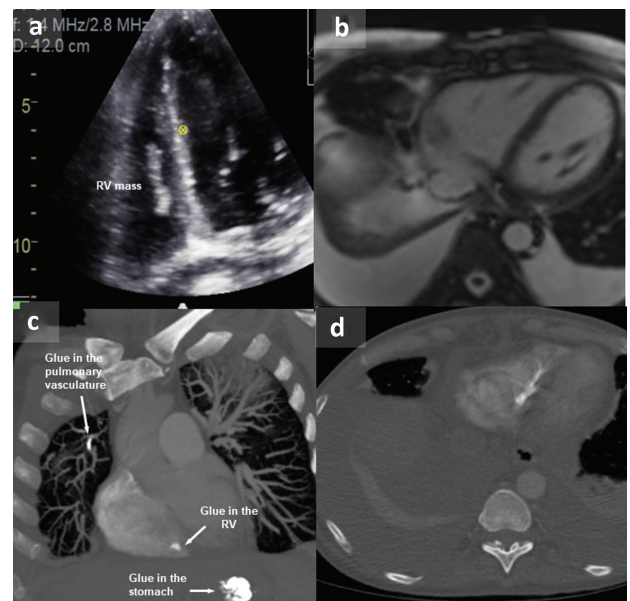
Multi-modality imaging showing right ventricle mass. a) Echocardiography showing an elongated structure in the right ventricle. b) Cardiac magnetic resonance imaging showing no masses in the right ventricle. c and d) Computed tomography multiplane reconstruction showing radio-opaque material in the right ventricle and in the pulmonary vasculature. RV = right ventricle.
